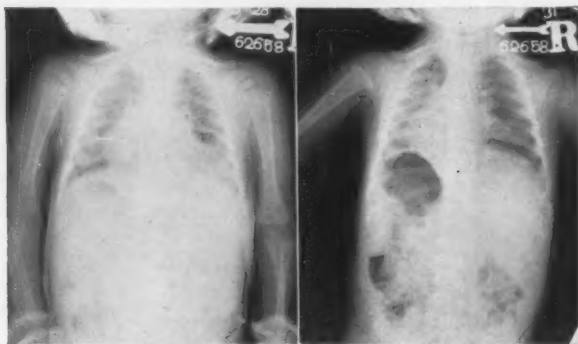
(A) Roentgenogram of infant boy, age 11 months, showing atelectasis of middle and lower lobe of right lung, with displacement of heart to the right; (B) Roentgenogram of the same patient, taken after bronchoscopic treatment and aspiration. Lung is fairly clear and the heart has gone back to the left.
